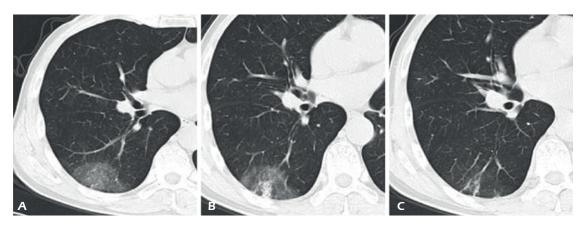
Chest CT images of a 37-year-old female COVID-19 patient at different stages. A, The patient had fever for 3 days. CT scan at the initial diagnosis shows focal GGO under the pleura in the dorsal segment of the right lower lobe (early stage). B, A re-examination of the chest CT on the 5th day of the disease course reveals wedge-shaped consolidation in the right lower lobe; C, Re-examination on the 12th day of the course shows that most of the lesions in the lower lobe of the right lung were resorbed at the same layer, leaving a few stripe shadows.
